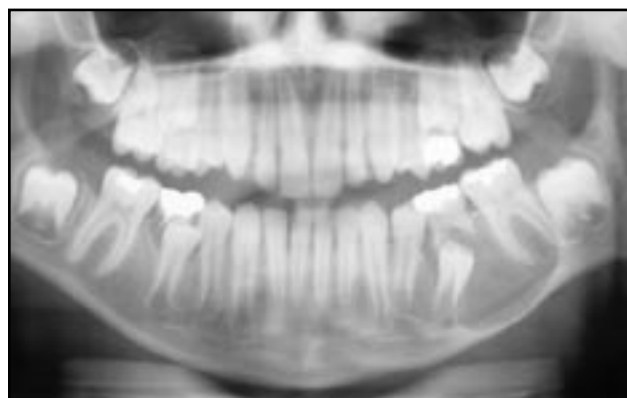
Case 1: Panoramic radiograph showing a large radiolucent area with displacement of the second premolar.
